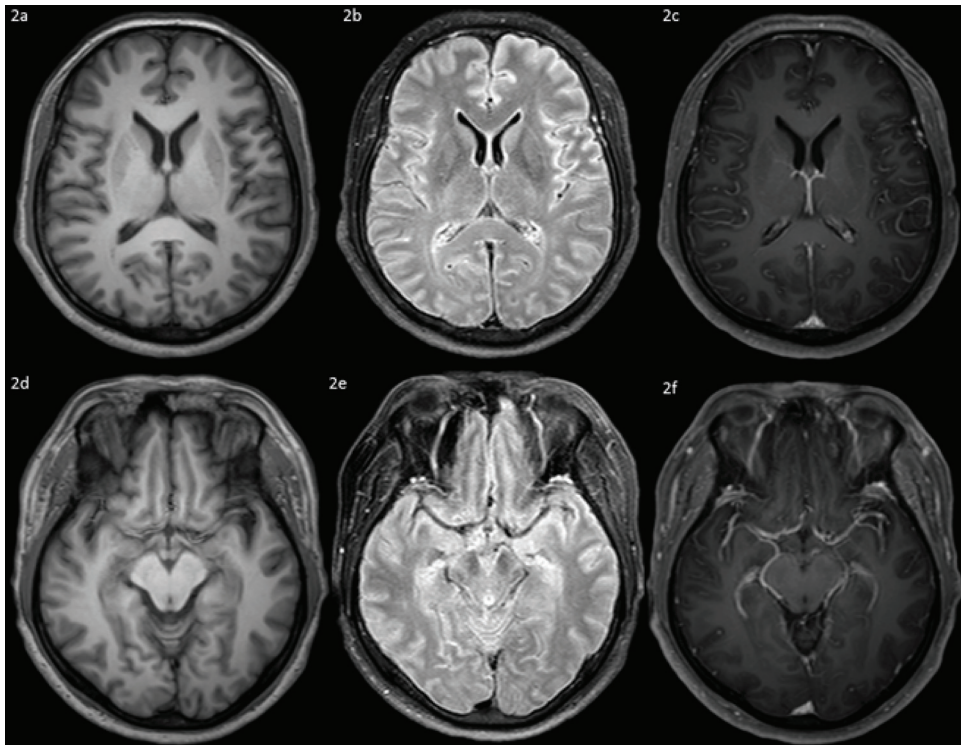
Brain MRI with Gadolinium (Gd) demonstrates diffuse leptomeningeal enhancement in T1W image with Gd (2c, 2f) without temporal lobes and intraparenchymal abnormalities in T1W (2a, 2d) and T2W FLAIR image (2b, 2e).
